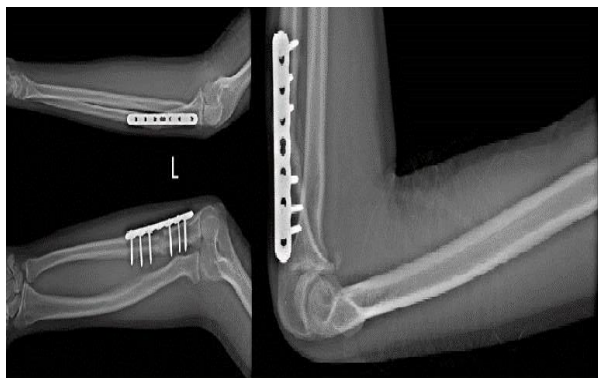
Left elbow x-ray at the three month follow-up
